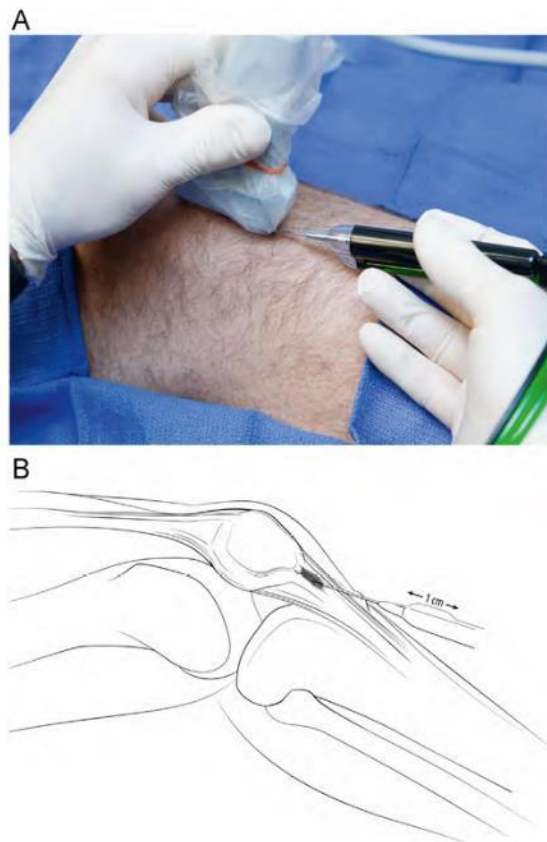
The probe is advanced into the lesion with ultrasound guidance. (A) The technique involves a to and fro “linear” movement of the probe as it is directed into the pathologic lesion (B). (Color version of figure is available online.)
